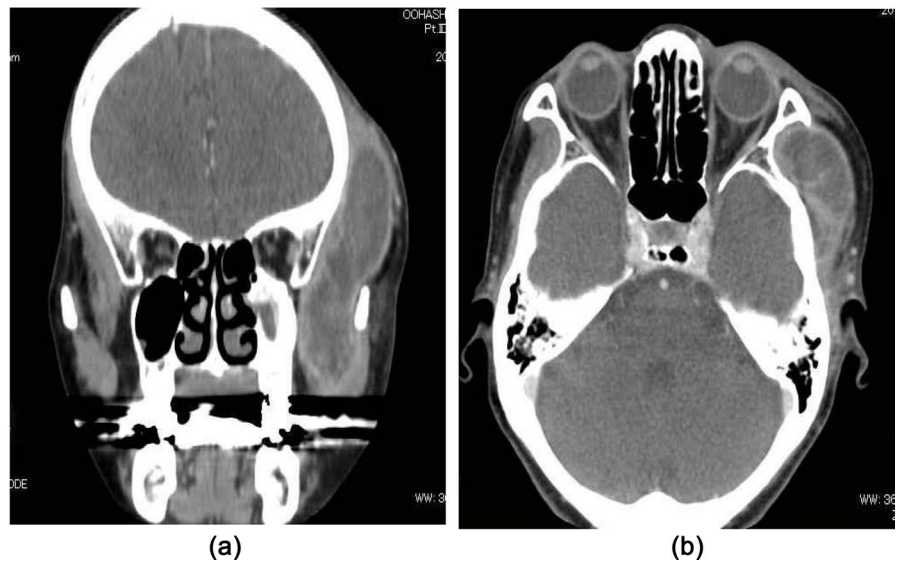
CT images showed low density area at the left side of the temporal area.
